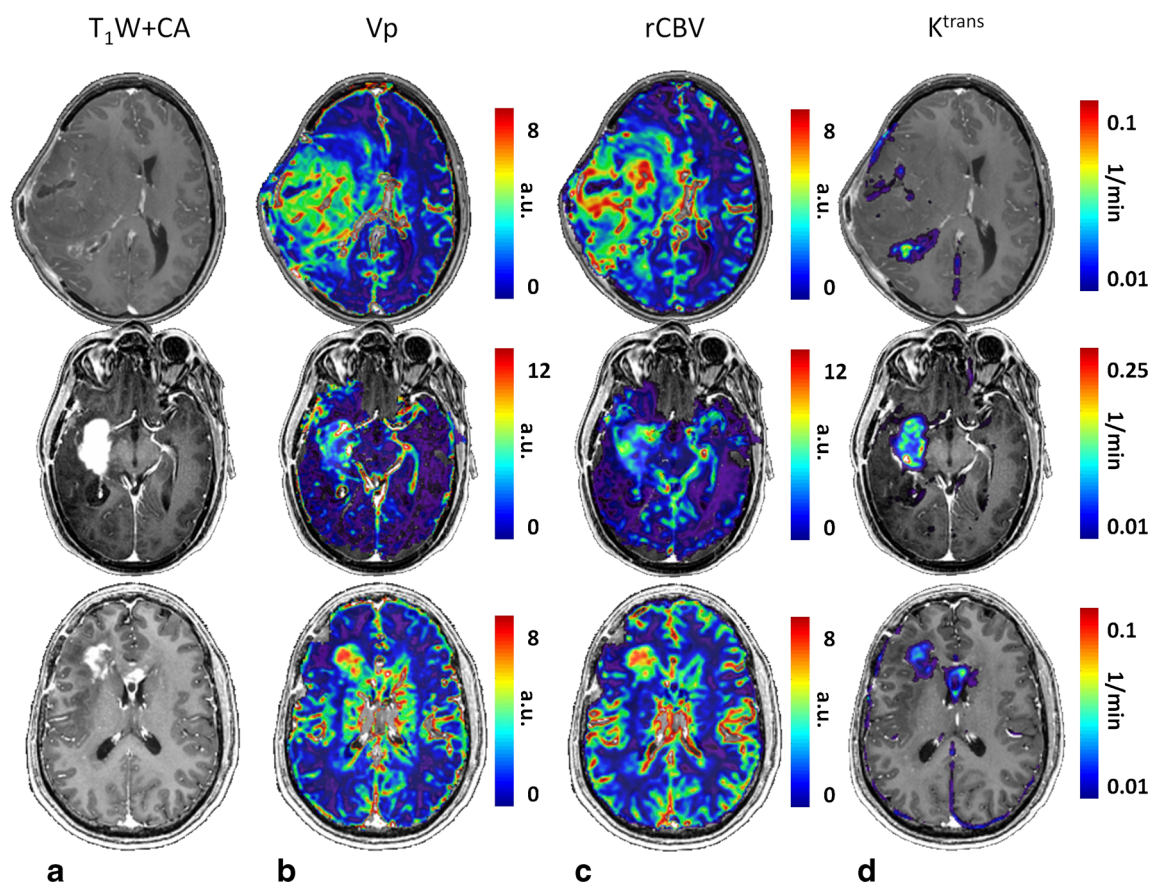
Representative data obtained from three patients with glioblastoma. T1-weighted image + contrast agent (T1W + CA) (a); DCE relative plasma volume (r_{vp}) maps (b) and DSC relative cerebral
